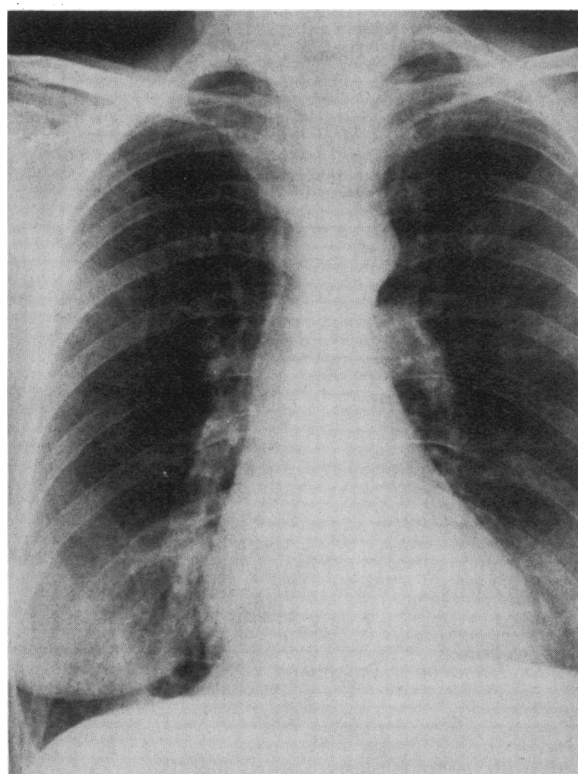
Admission x-ray of chest showing lesion below right inferior pulmonary artery.
